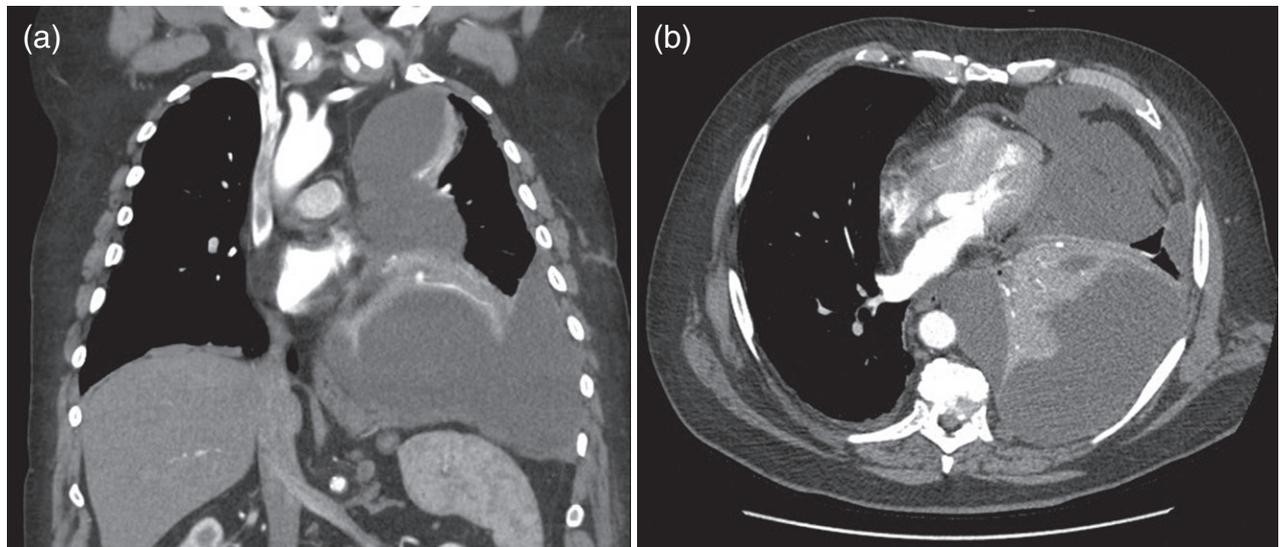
Computed tomography thorax (coronal and axial views) shows left-sided, multiple, large loculations as a sequel to failed surgical pleurodesis in a patient with malignant mesothelioma. The locules are separated by thick septations that prevent adequate fluid drainage and lung re-expansion. This patient was managed with an indwelling pleural catheter that provided effective drainage and relief of breathlessness.
